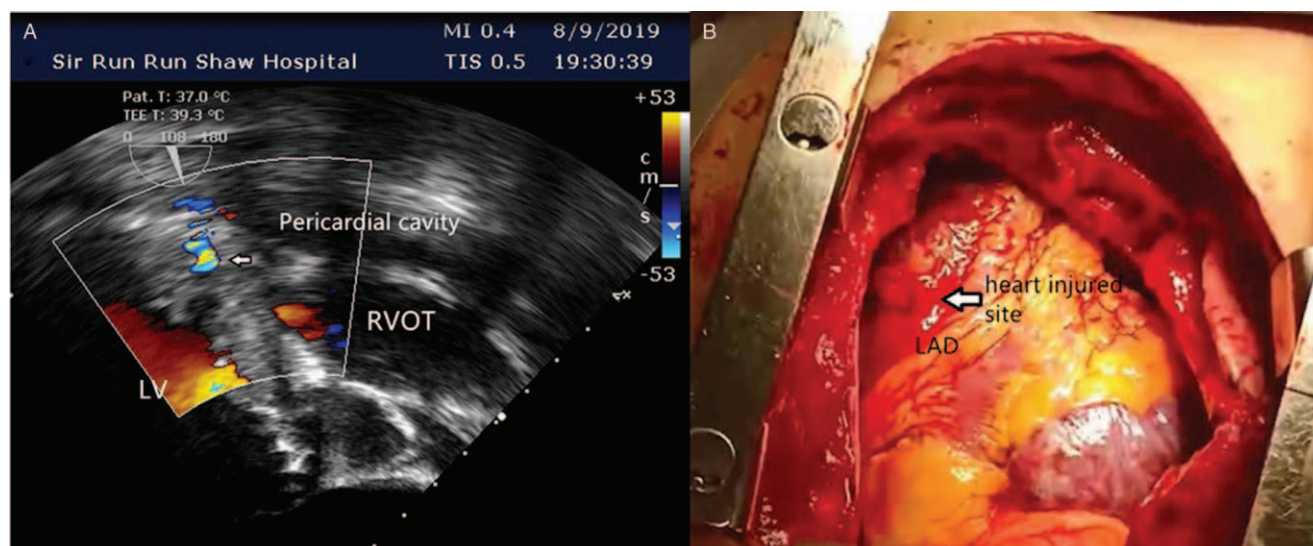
(A) The Color Flow Doppler imaging showed a bundle of blood from the left ventricle ejected to the pericardial cavity. (B) On the left ventricular surface, we found a 1 cm gap, which was 8 mm away from the left anterior descending branch (LAD) and parallel with the ventricular septum. Blood ejected to outside of the left ventricle from the gap with every heartbeat. LV: Left ventricle; RVOT: Right ventricular outflow tract.
